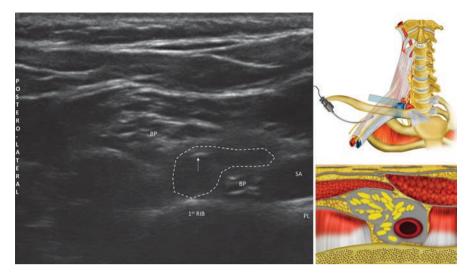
Ultrasound of supraclavicular area and hydrodissection, titrated with D5W opening space and confirming the position of needle tip inside brachial plexus sheath. *BP* brachial plexus; *SA* subclavian artery; *PL* pleura; arrow – needle; dashed line – D5W spread
